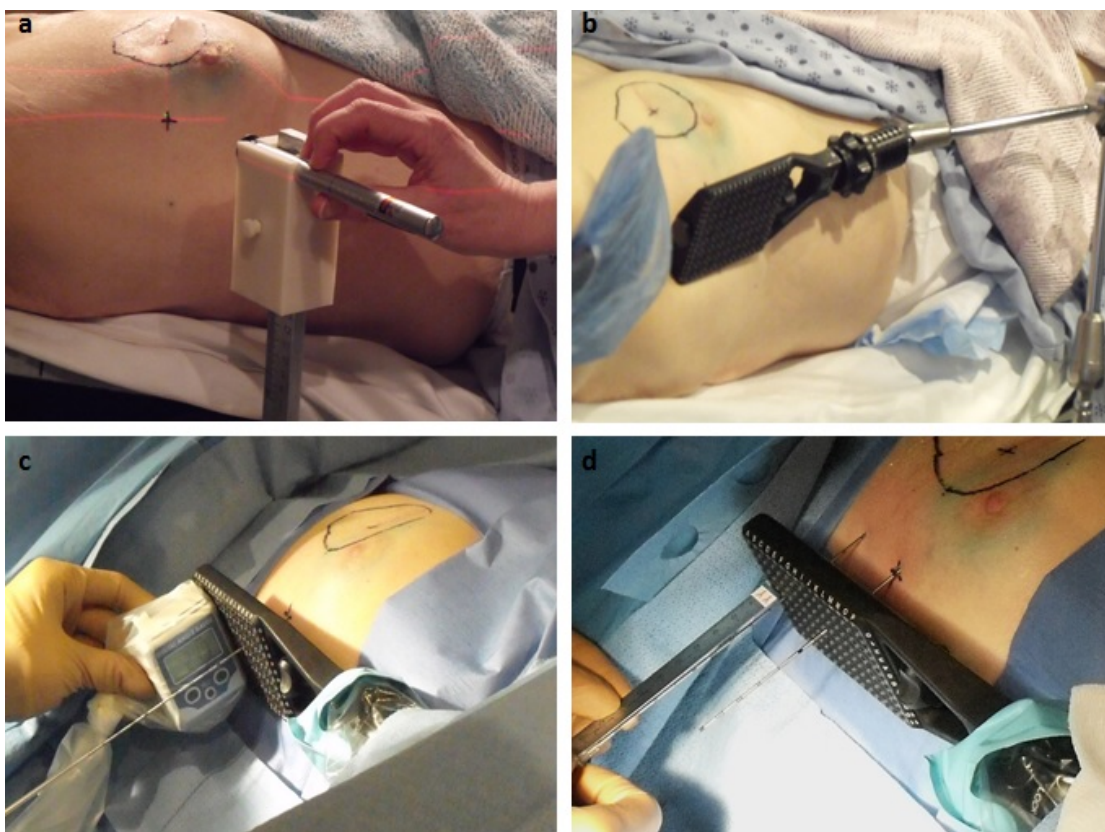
PBSI delivery procedure. (a) The fiducial needle entry point is marked using the CT rooms lasers and verified using a portable laser. (b) The set up is recreated in the OR and the template is set into it's planned position. (c) The fiducial needle is inserted and final adjustments to the template positioning are made. (d) Loaded needles are inserted into their planned template positions with depths verified by the protrusion distance.
